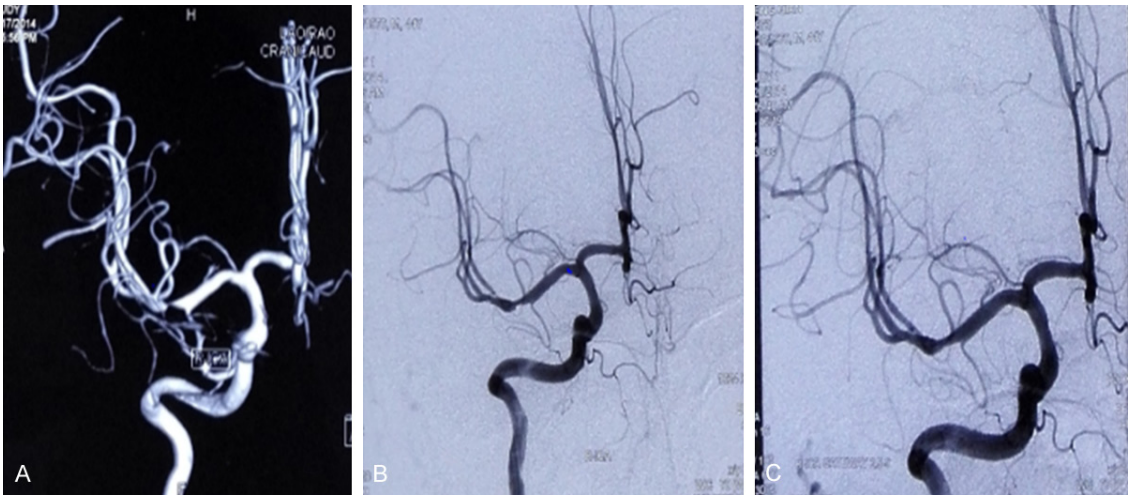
Right MCA stent implantation (A. Preoperative 3D image; B. Preoperative radiography; C. Postoperative radiography).
